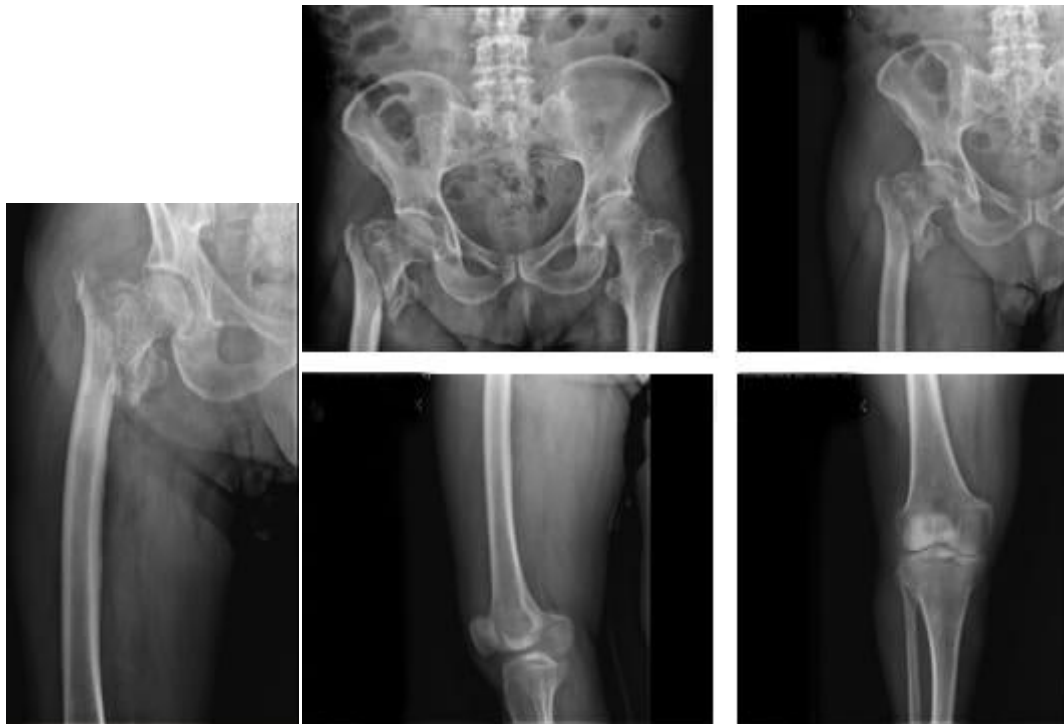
Preoperative conventional radiographies.
